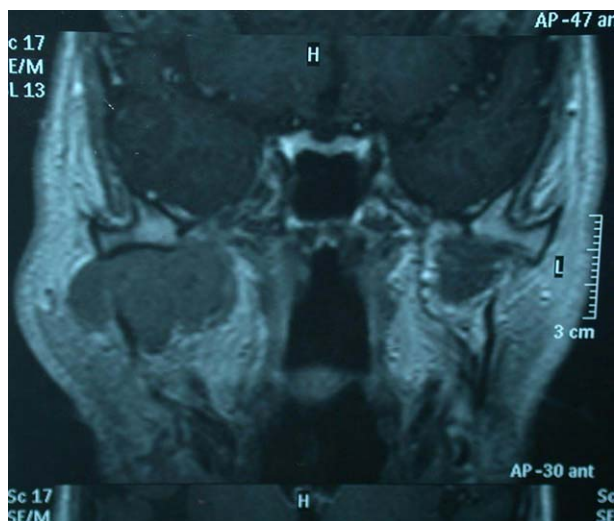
Magnetic resonance imaging (MRI) scans with contrast revealed a bulky lesion in the right infratemporal fossa with extensive destruction.
